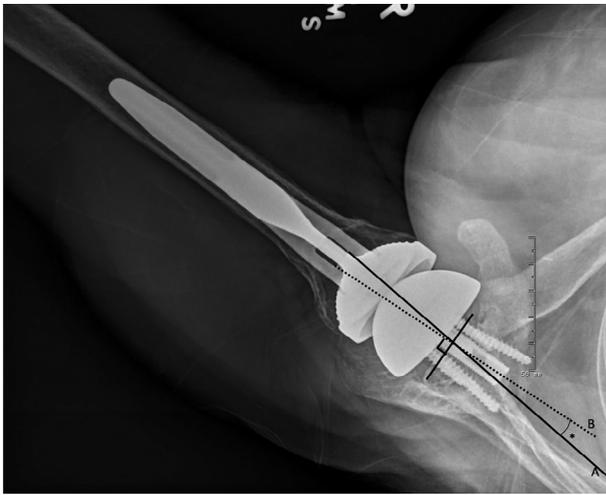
Axillary view of shoulder, demonstrating measurement of glenosphere version. A line is drawn along the body of the scapula (*solid line, A*), similarly to the technique described by Friedman et al¹⁰ for computed tomography measurement, and a second line is drawn along the central peg of the glenoid baseplate (*dotted line, B*). The angle between these 2 lines (*asterisk*) represents the amount of version of the glenoid implant.¹¹
